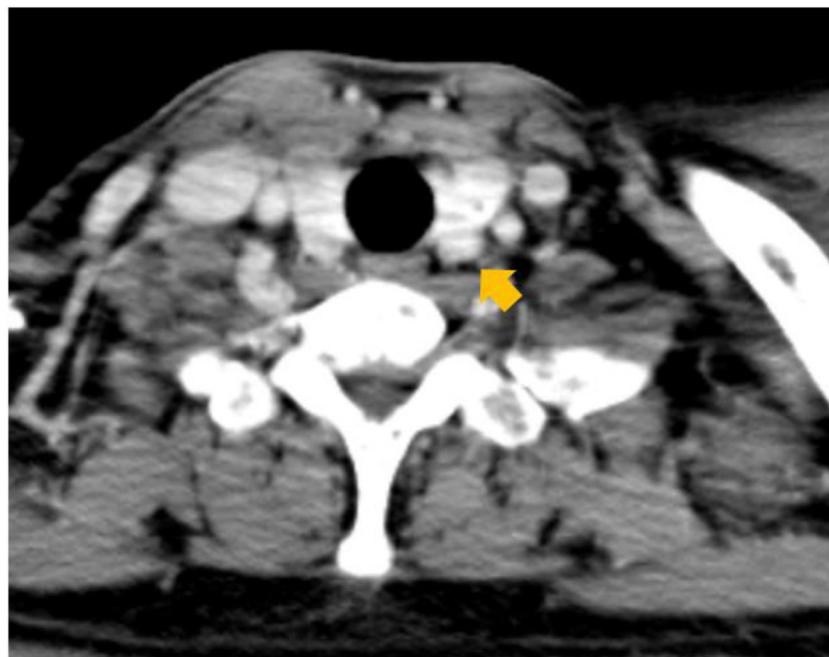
An enhanced CT of the neck showed a 11 × 10 mm well enhancing and circumscribed soft tissue mass abutting posterior aspect of the left thyroid lobe. (arrow).
